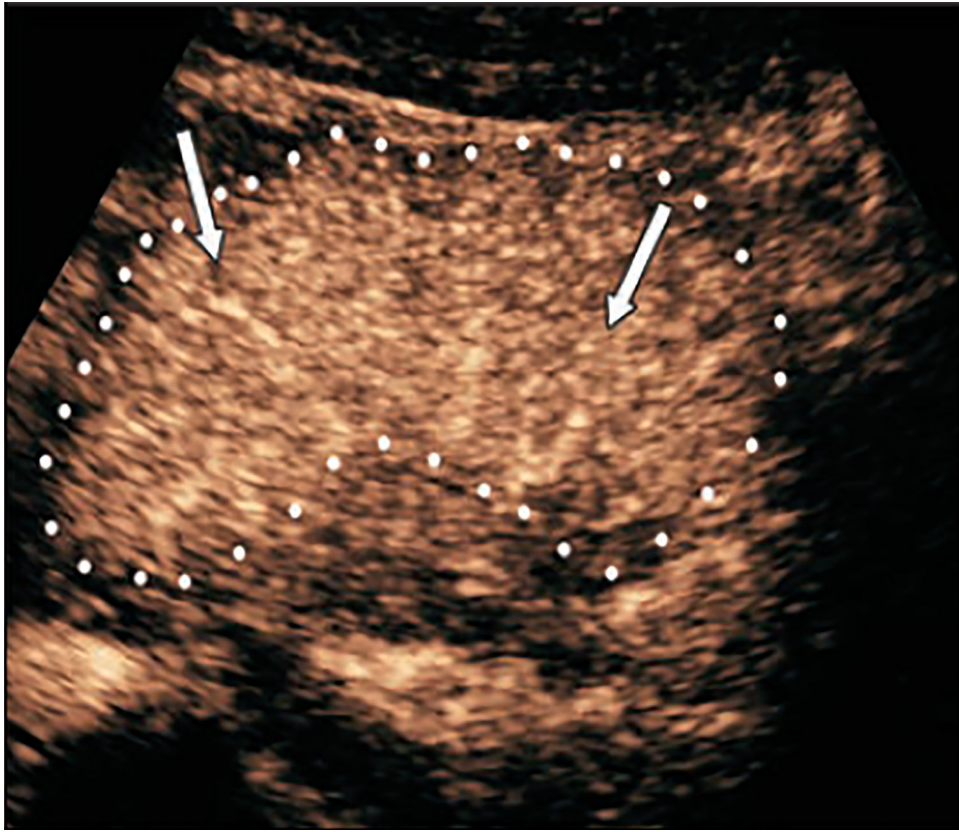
26-year-old man who had pancreas graft (area within *dotted outline*) with venous insufficiency. Contrast-enhanced ultrasound image interpreted by reader as showing that pancreatic parenchyma (*arrows*) had persistent homogeneous enhancement at 2 minutes 30 seconds after injection of contrast medium, suggesting impaired venous washout of contrast medium. Patient was found to have large splenic vein thrombus.
